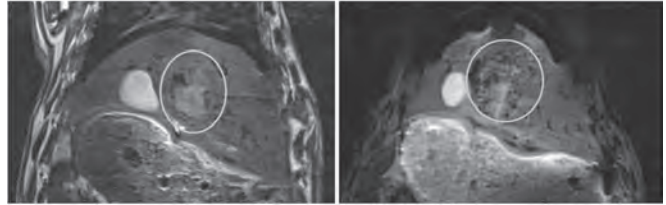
Pre (left)- and post (right)-procedural T2-weighted imaging shows areas of signal loss at the tumor due to the proper delivery of our microspheres.
